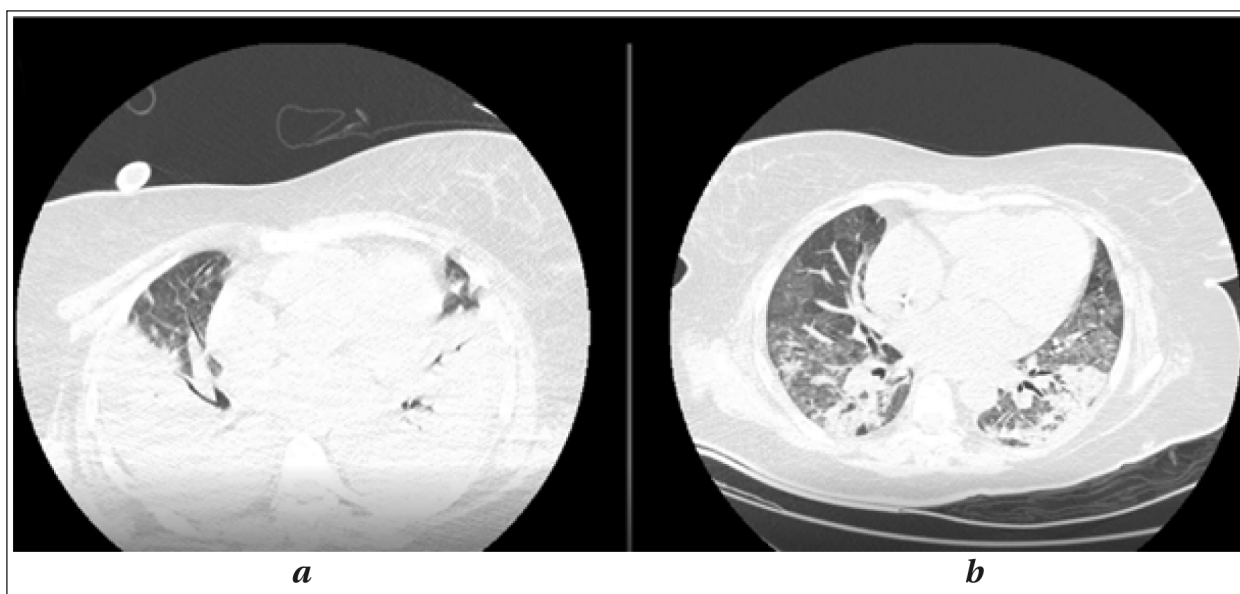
The evolution of CT before (a) and after (b) the ECMO session lasting 19 days.
